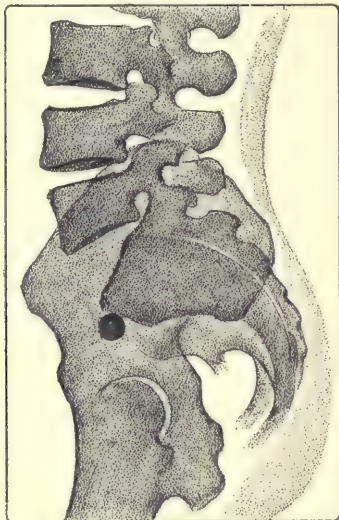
The tracing of this radiograph of the same patient as in Fig. 187 shows us the pelvis seen from the left side, and shows the projectile as placed on the promontory. We know now exactly its anatomical position.
